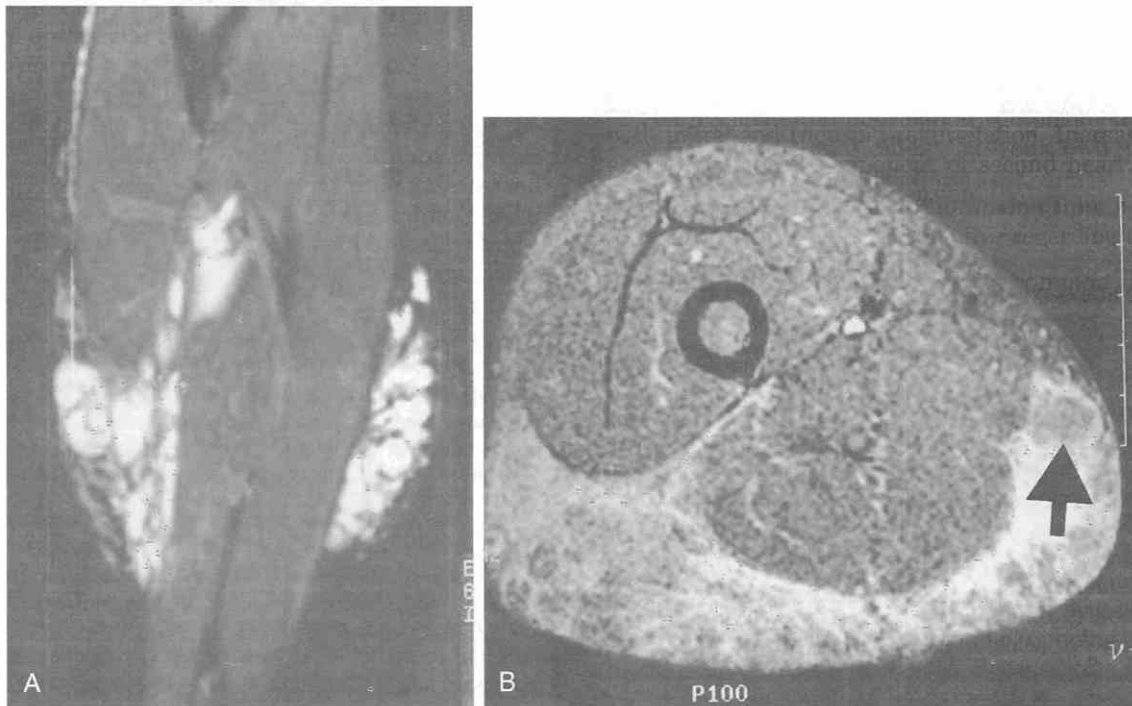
Lymphangioma of the thigh in a 7-year-old boy. A, Coronal inversion recovery image (TR = 4000 msec, TE = 25 msec, TI = 150 msec) shows a diffuse, multilobular, high-signal-intensity lesion principally within subcutaneous tissues. B, Postgadolinium axial T1-weighted image (TR = 650 msec, TE = 19 msec) with fat saturation shows minimal enhancement within interstices of the subcutaneous tissue. No soft tissue mass is defined. The fluid-containing cystic spaces do not enhance, but they do show peripheral enhancement (arrow).
